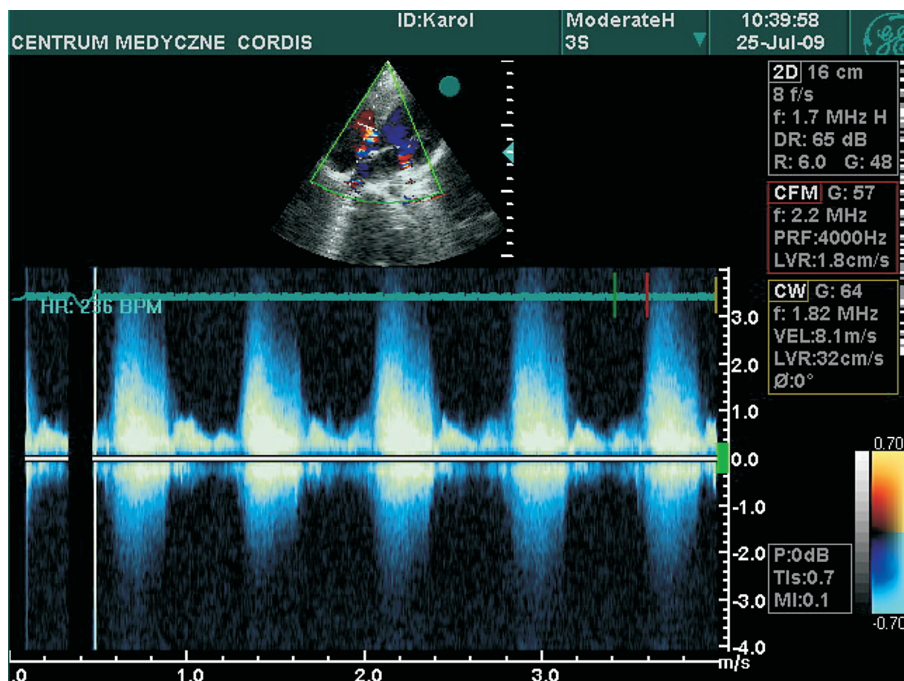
Echocardiography. L-R shunt across ventricular septal defect (VSD)
